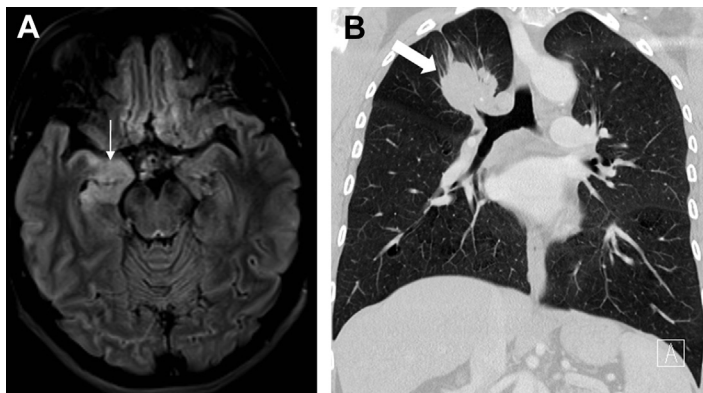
Anti-Hu antibody limbic encephalitis due to SCLC. Axial FLAIR image (A) shows hyperintensity in the right medial temporal lobe (arrow). The coronal reconstructed image of the chest (B) shows a mass lesion (arrow) in the right upper lobe, biopsy-proved SCLC.
